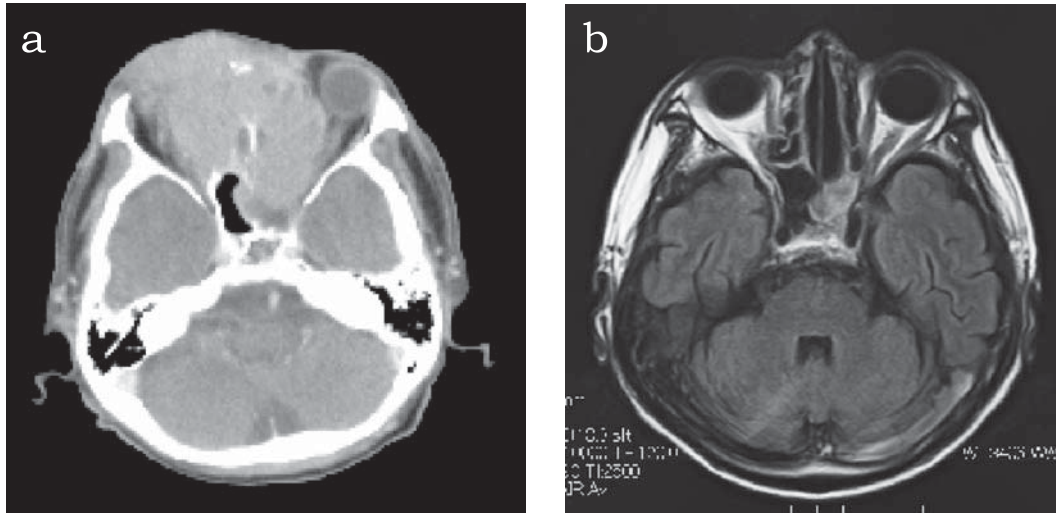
Contrast-enhanced computed tomography revealed a tumor extending from the ethmoidal sinus to the nasal cavity, the right orbital cavity, and the anterior cranial fossa (1a). Brain magnetic resonance imaging after three courses of R-THP-COP chemotherapy revealed that the tumor in the ethmoidal sinus remarkably decreased in size. Definite infiltrated regions were not detected in the cranial region (1b).
